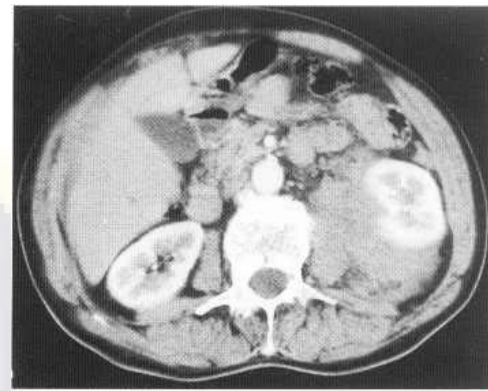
Contrast CT showing large predominantly posterior perinephric haemorrhage.
